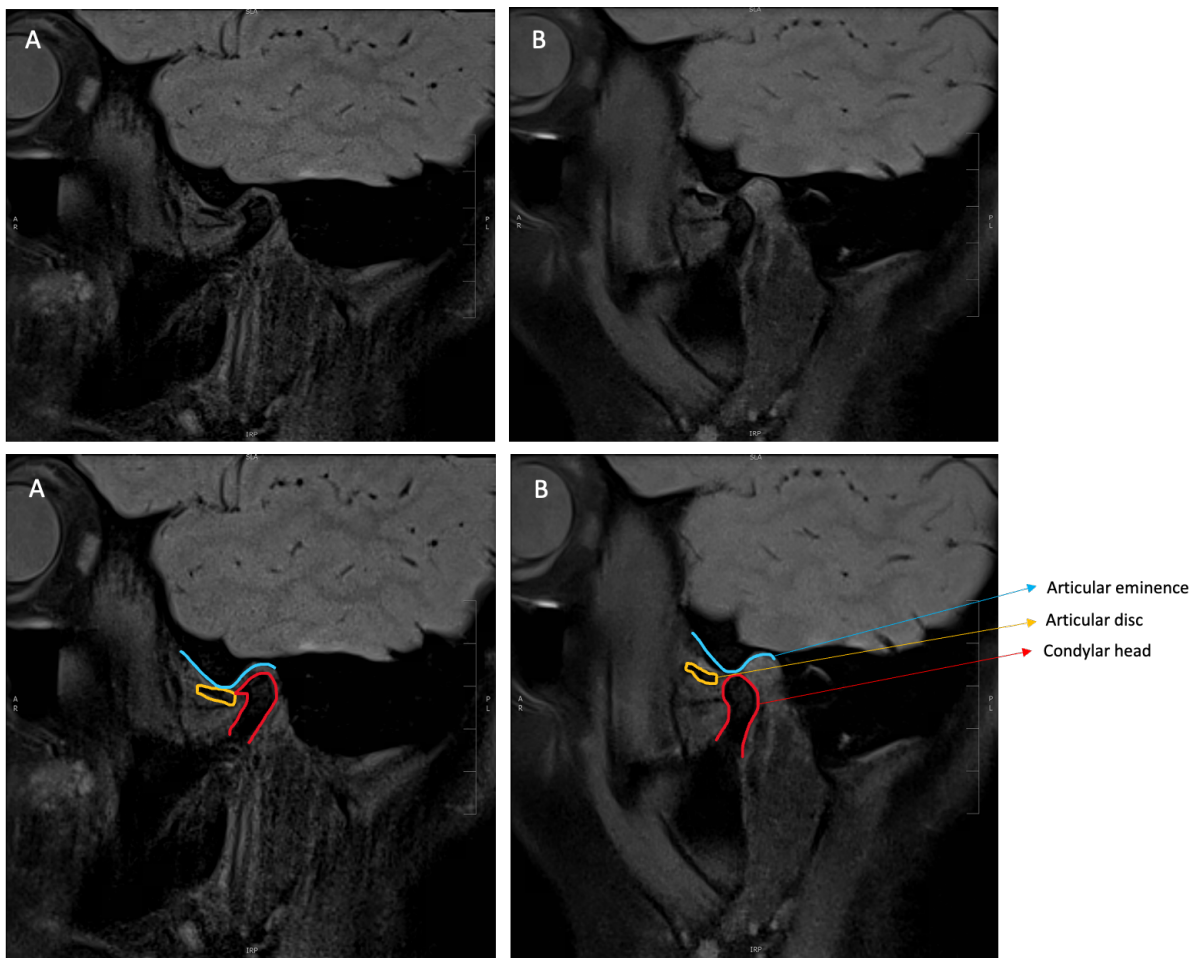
MRI sagittal views of left TMJ. MRI sagittal views of left TMJ in A) closed mouth and B) open mouth positions. Note the persistent ADDwoR.
